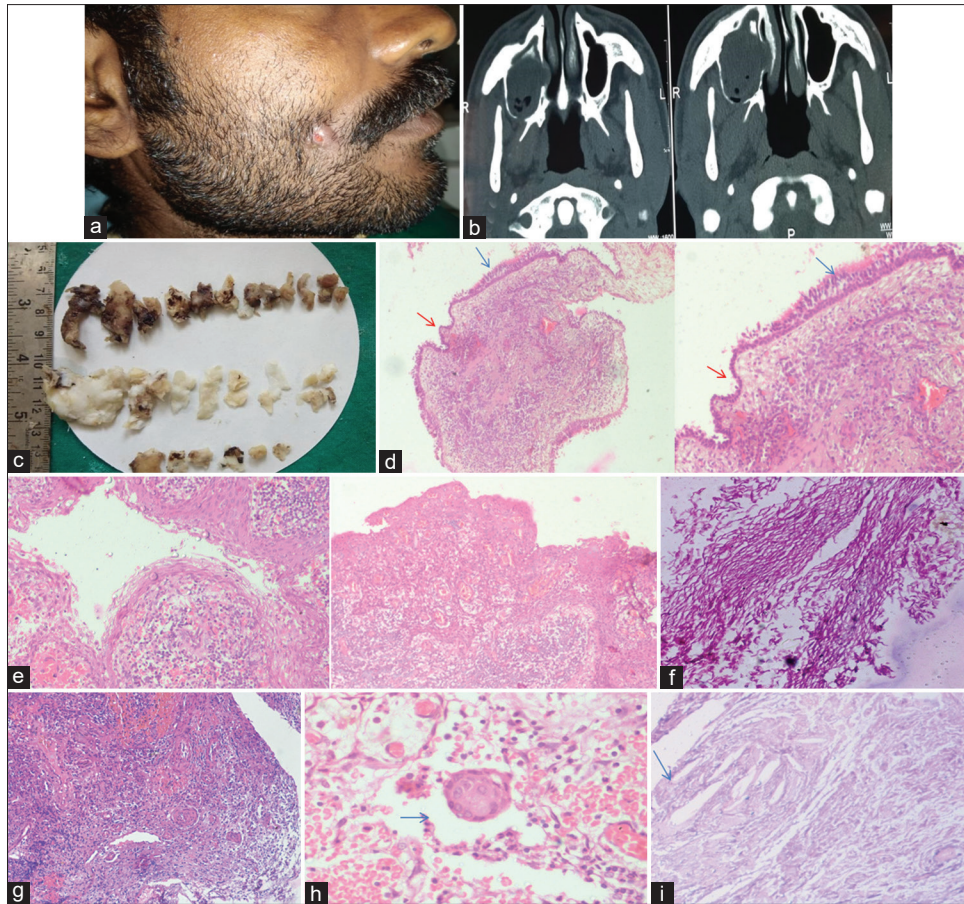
(a) Infected maxillary sinus tract opening and discharge on right side of the face. (b) Coronal view: computed tomography revealed a hypodense osteolytic space-occupying lesion with a deviation of the nasal septum. (c) Grossly, it exhibits brownish and creamish white in color. (d) In $\times 10$ view (left), $\times 20$ view (right), epithelium exhibits a marked transition from pseudostratified ciliated columnar respiratory epithelium (blue arrow) to stratified squamous epithelium (red arrow) (e): $\times 20$ view (left) revealed a stratified squamous epithelium with lamellar sheets of keratin supraepithelially. $\times 10$ view (right) exhibits stratified squamous epithelium with inflammatory cells and blood capillaries. (f) $\times 10$ view exhibits loose sheets and flakes of dense eosinophilic, acellular, and anucleated areas resembling orthokeratin supraepithelially (g) $\times 10$ view shows squamous metaplasia and areas of hemorrhage in the fibrocollagenous connective tissue stroma (h) $\times 20$ view exhibits multinucleated giant cell in the connective tissue (i) $\times 10$ view revealed cholesterol clefts in the connective tissue stroma
